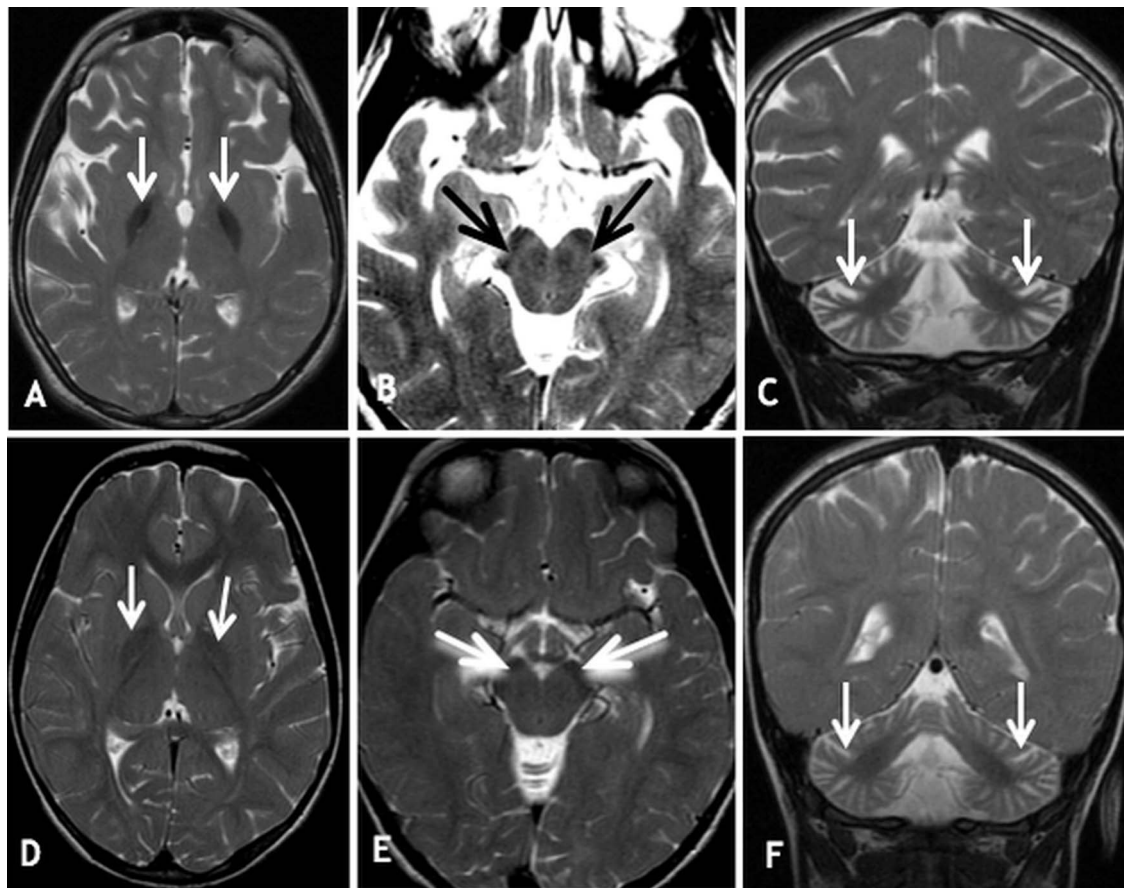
Neuroimaging examples. (A,B,C) Patient 7 at 10 years old. MRI brain axial T2WI (A) shows significant dark signal intensity at globus pallidus bilaterally consistent with excessive iron deposition (arrows) and (B) dark signal intensity in the substantia nigra at the level of the midbrain, also consistent with excessive iron deposition (arrows). Coronal T2WI (C) shows dilated cerebellar folia (arrows) due to cerebellar atrophy. (D, E, F) Patient 8 at 4 years old. MRI brain axial T2WI (D) shows mild dark signal intensity at globus pallidus bilaterally consistent with mild iron deposition (arrows) and also (E) at the substantia nigra (arrows) at the level of the midbrain, also consistent with iron deposition. Coronal T2WI (F) shows dilated cerebellar folia (arrows) due to cerebellar atrophy.
